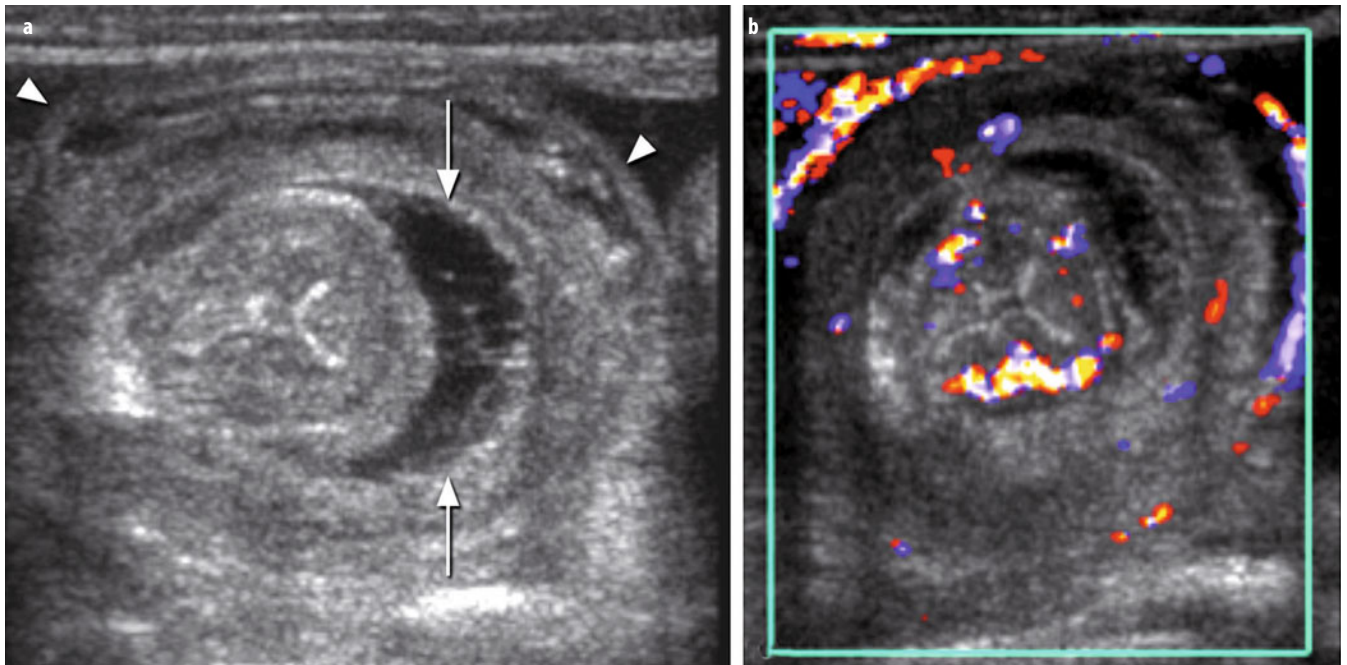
a, b. a Grey-scale and b Doppler views of an ileocolic intussusceptions seen in transverse view. a Arrows indicate a moderate amount of fluid between the layers of the intussusceptum; the amount of hyperechoic mesenteric fat is less than in Fig. 9. Arrowheads indicate the markedly thinned intussusceptions along the periphery, which is also separated from the intussusceptum by some fluid. b Doppler examination reveals very good flow to the intussusception, which was easily reduced by air enema
